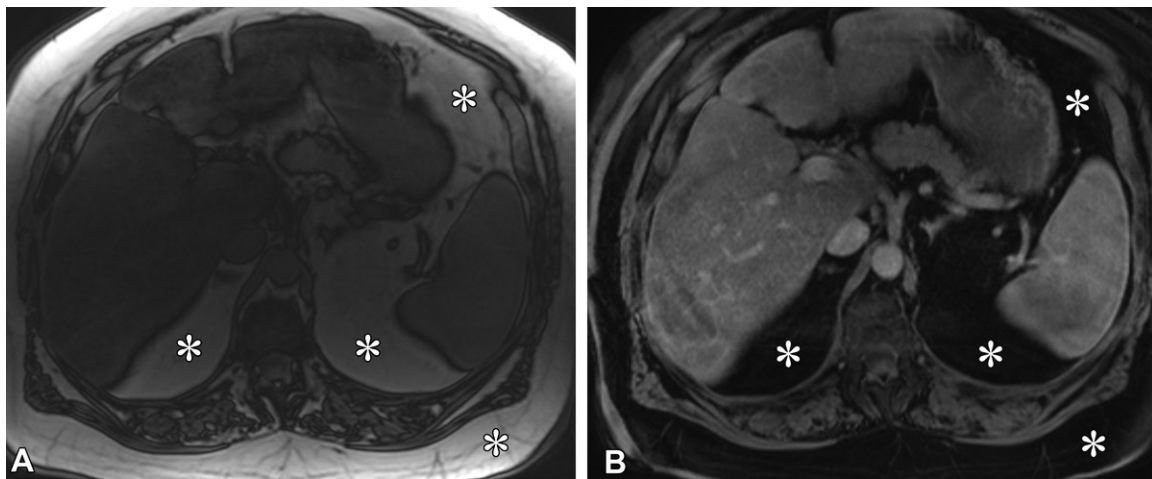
Failure of frequency-selective fat saturation in a 59-year-old-man with HCC. (A) Axial precontrast T1-weighted MR image shows global failure of fat suppression (*). The image is similar in appearance to that seen with an opposed-phase sequence owing to this sequence typically being performed with the shortest possible TE. (B) Axial T1-weighted delayed phase water-only Dixon MR image shows successful fat suppression (*), which can be used before and after contrast agent administration..
